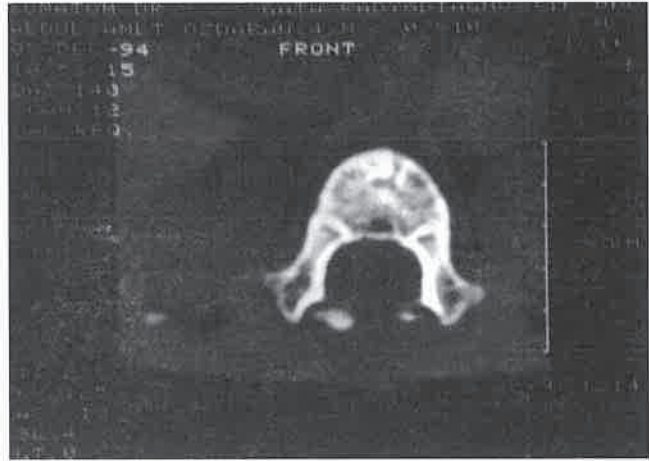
Postoperative CT-scan showing total laminectomy and spinal cord at thoracic 8.
